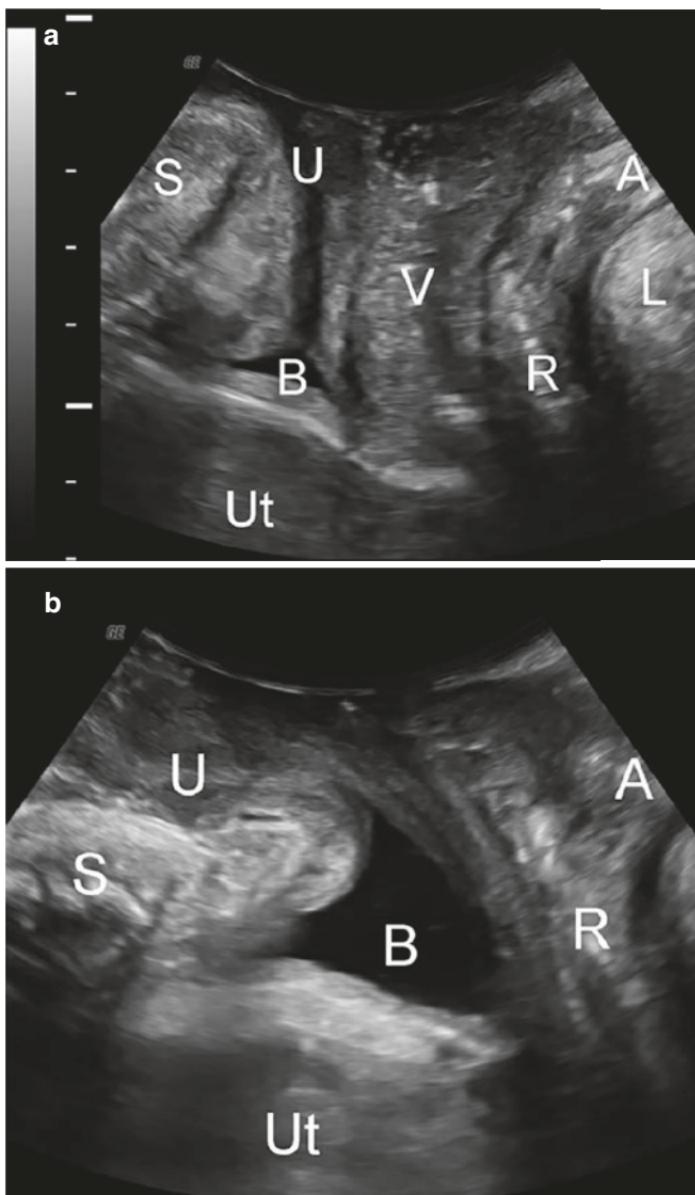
Determination of bladder neck descent and retrovesical angle: ultrasound images show the midsagittal plane at rest (a) and on Valsalva (b). *S* symphysis pubis, *U* urethra, *B* bladder, *Ut* uterus, *V* vagina, *A* anal canal, *R* rectal ampulla, *L* levator ani (From: Dietz [6], with permission)
